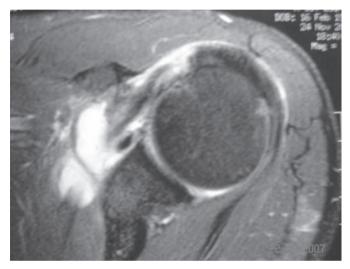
Magnetic resonance image showing subscapular rupture and biceps dislocation.
